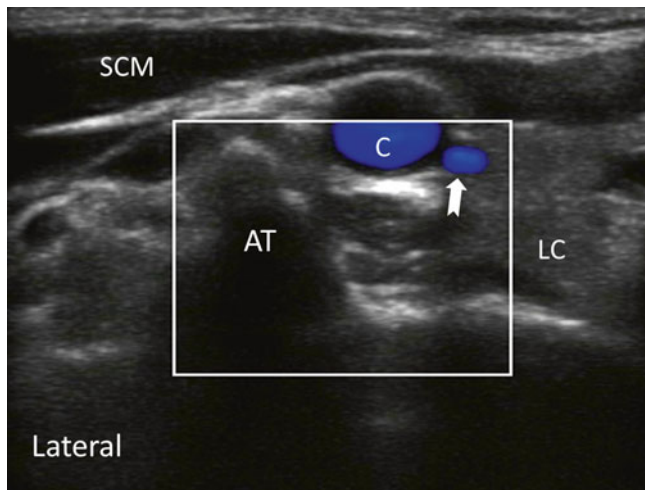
Ultrasonographic image of neck at C6 level on the right side showing a vessel in the short axis (*bold arrows*). *LC* longus colli muscle, *C* carotid artery, *SCM* sternocleidomastoid muscle, *AT* anterior tubercle (Reproduced with permission from Philip Peng Educational Series)
